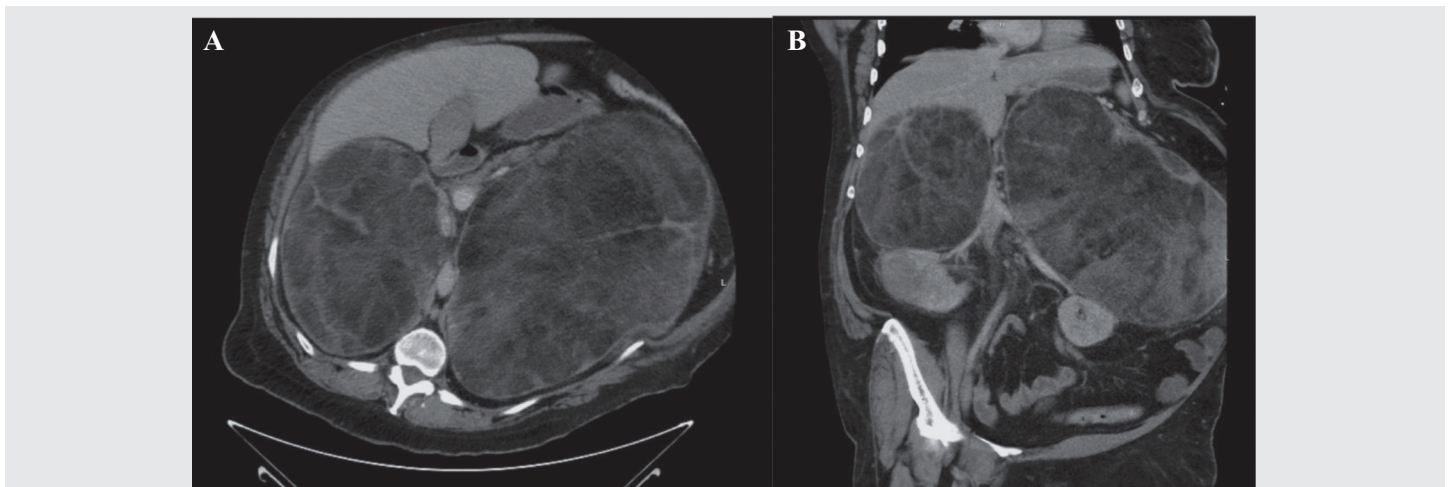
A: Contrast-enhanced computed tomography of the abdomen and pelvis in the axial view revealing large bilateral adrenal masses containing macroscopic fat and soft tissue components. The right adrenal lesion measured $13.6 \times 19.2 \times 15.6$ cm, while the left measured $28.3 \times 20.9 \times 29.6$ cm. These findings were most consistent with adrenal myelolipomas; however, retroperitoneal sarcoma and lymphoma were considered as part of the differential diagnosis. B: Coronal view of the large bilateral adrenal mass.
